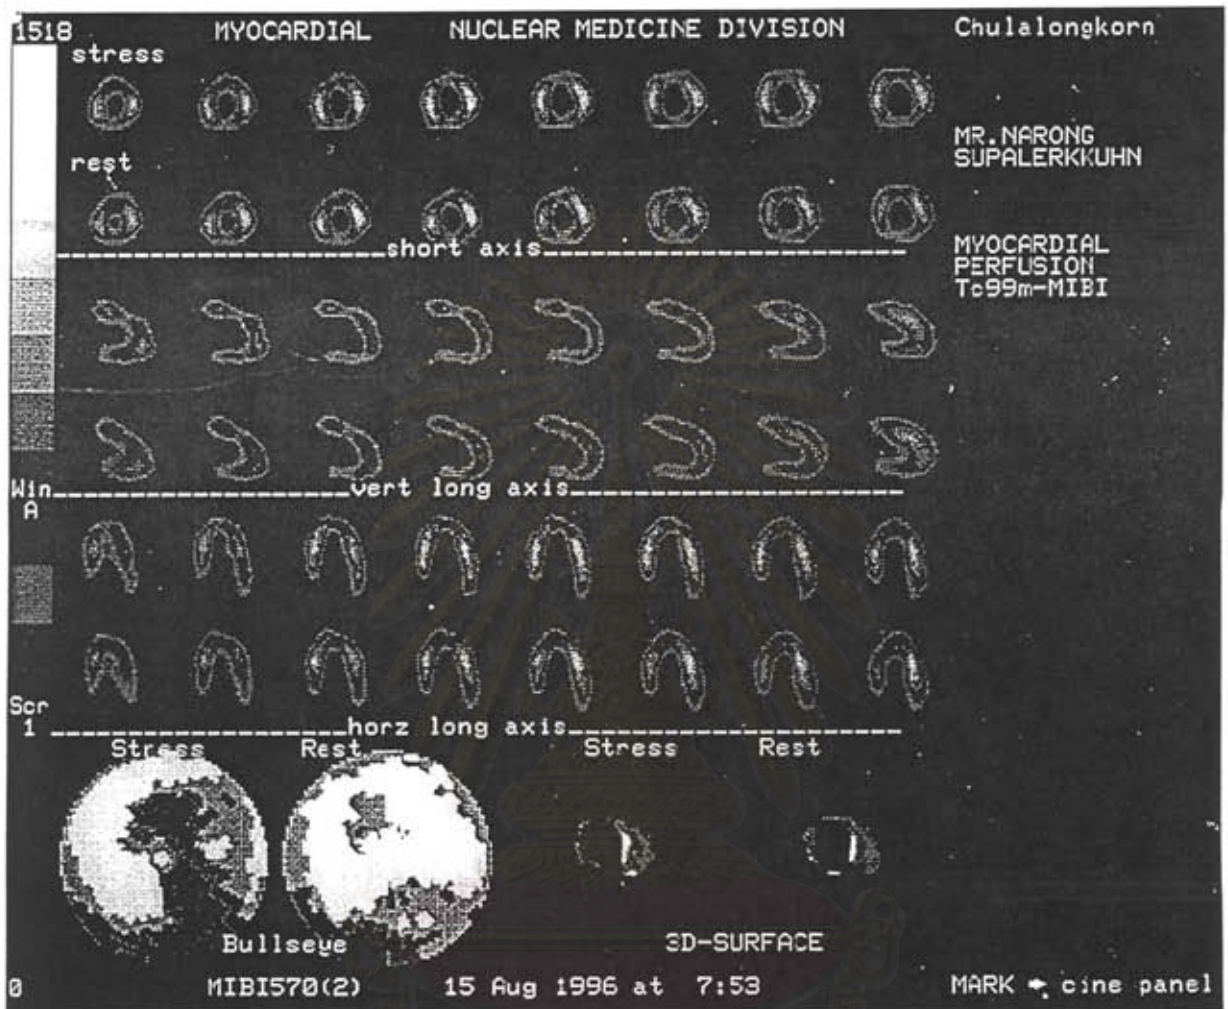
Stress and rest Tc-99m Sestamibi SPECT imaging after PTCA month 1 from a 59 year male patient showing much improvement of reversible filling defect (myocardial ischemia) at anterolateral and apical wall
